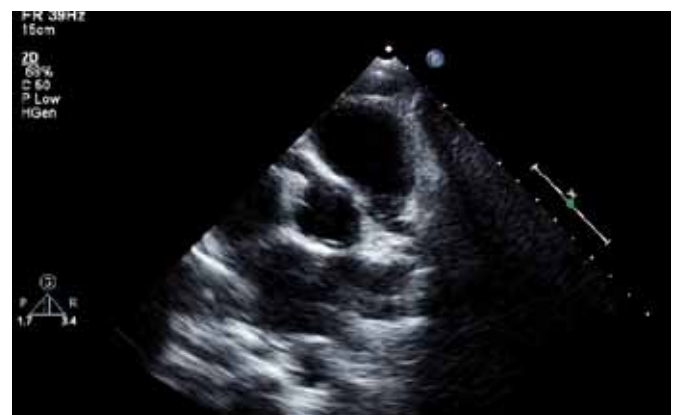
From parasternal short-axis view, a markedly dilated right coronary artery (RCA) can be seen.
